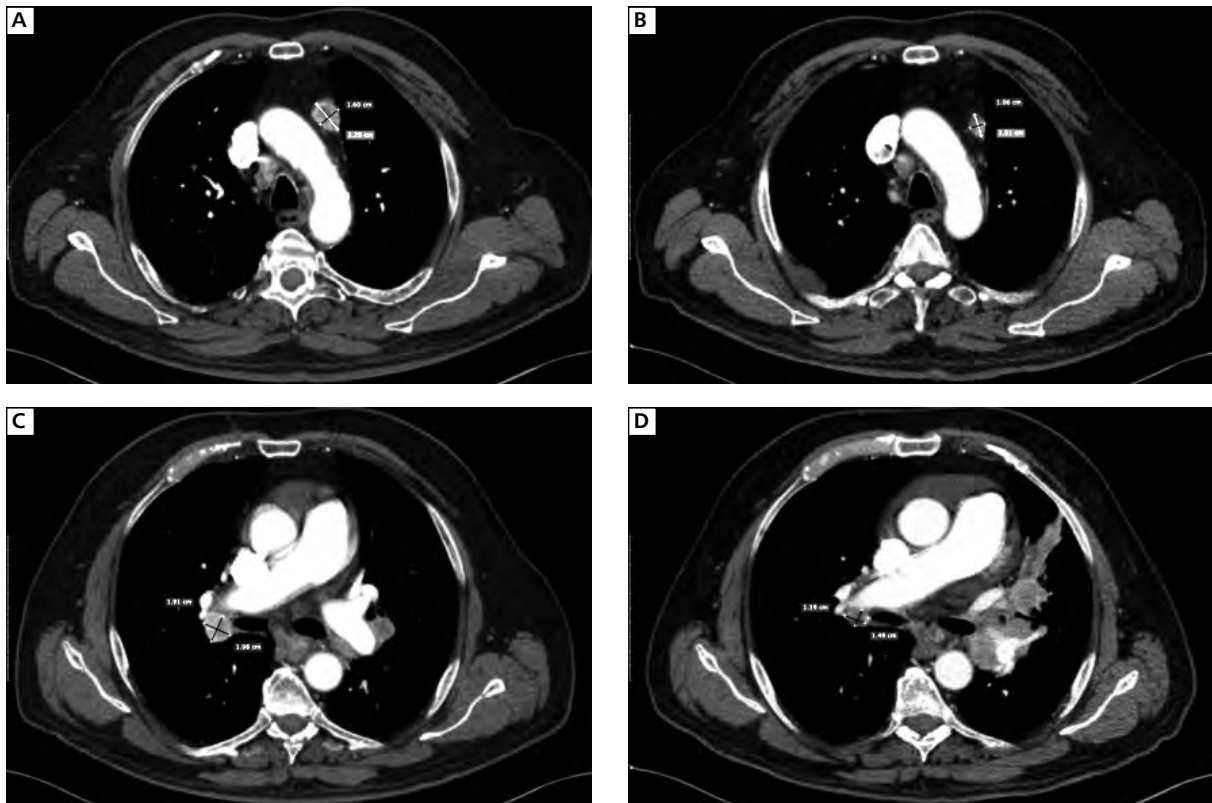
Example of a dissociated response. Man, 60 years old, in the course of immunotherapy for metastatic clear cell renal cell carcinoma carcinoma. Left side (A, C) — CT scan before initiating treatment. Enlarged mediastinum and internal right and left lung lymph nodes. Right side (B, D) — CT scan after initiating immunotherapy. A clear decrease in size of the mediastinum and internal right lung nodes with a simultaneous increase in the size of the internal right lung lymph nodes
